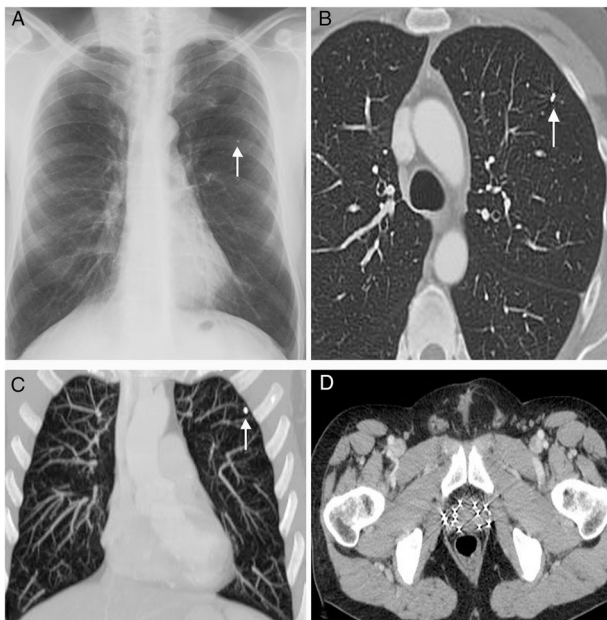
(A) Posteroanterior chest radiograph shows a small metallic density in the left lung (arrow). (B) and (C) Axial (B) and coronal MIP (maximum intensity projection), (C) CT images (lung window) confirm that the metallic density corresponds to a single migrated brachytherapy seed in the left upper lobe (arrow). (D) Axial CT image at the level of the pelvis shows multiple brachytherapy seeds within the prostate.
